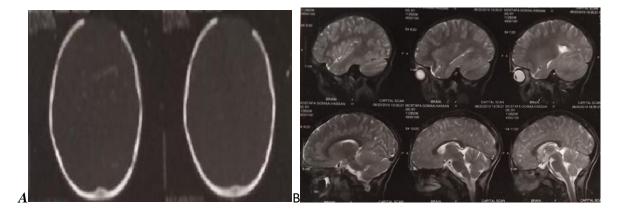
A- shows postoperative axial CT brain with bone removed. B- MRI sagittal view post-surgical excision of diseased bone with no residual and no extra or intracranial collection
